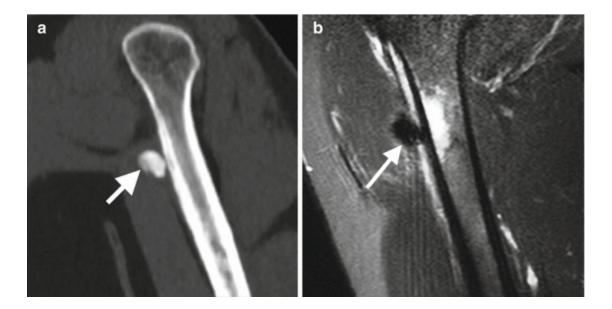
Calcific tendinitis of the pectoralis major tendon at the humeral insertion in a 48-year-old-man with intense pain that limits daily physical activity. Coronal reformatted CT image (a) and coronal fat-suppressed T2-weighted MRI (b) show calcification (arrow), erosions and cortical irregularity with medullar edema
